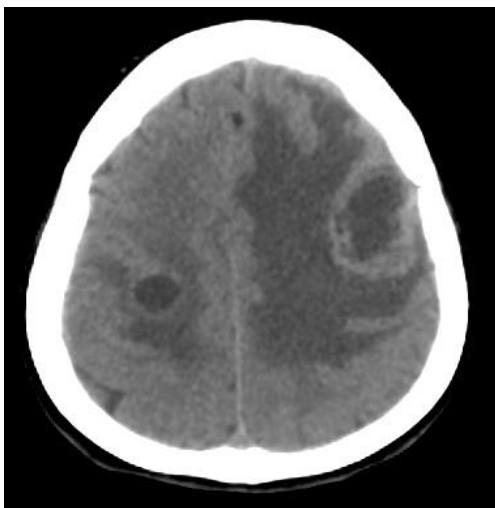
CT scan Exam with contrast display multiple metastases lesions, with > 3 cm in largest diameter.
